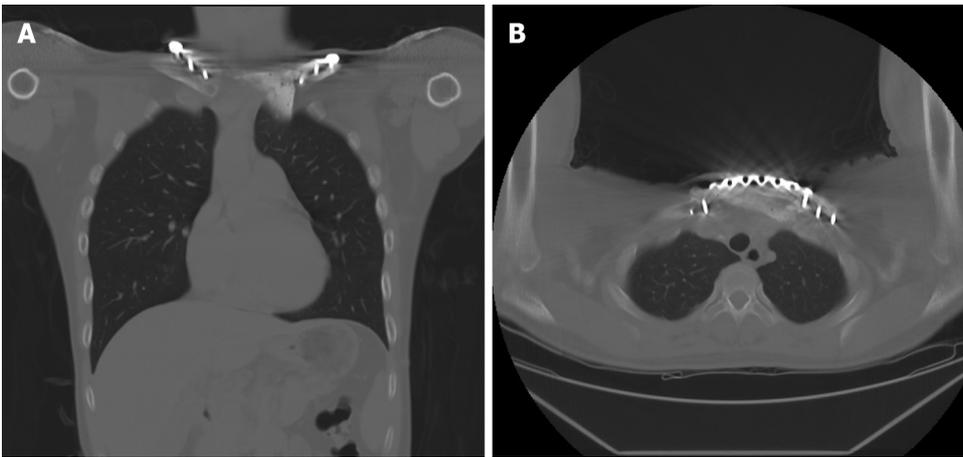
Coronal and axial views of computed tomography at 1-year follow-up revealing absence of local tumor recurrence. A: Coronal; B: Axial.
